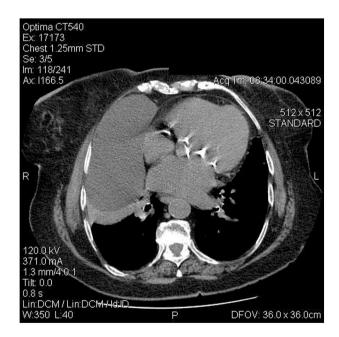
Urgent thorax and abdomen contrast CT-scan depicting an enormous pericardial cyst (6.6 cm $\times$ 14.7 cm) located at the right cardiophrenic angle, causing atelectasis of the right middle and lower lung lobe.
